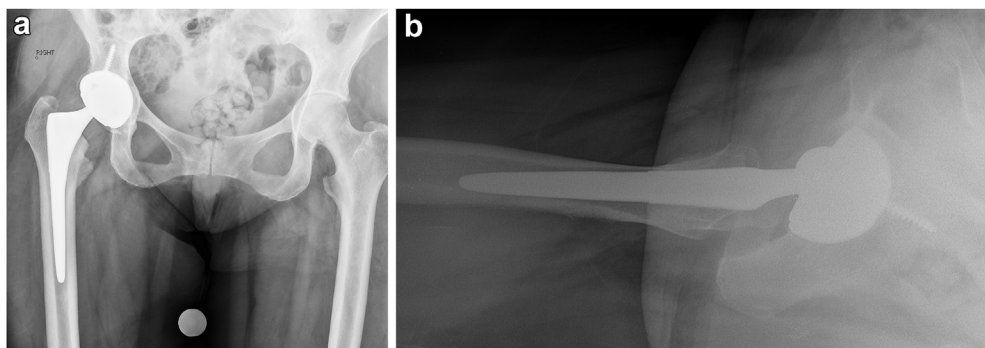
Postoperative AP (a) and direct, cross-table lateral (b) radiographs of a primary THA with a well-seated modular DM construct and MDM liner.
